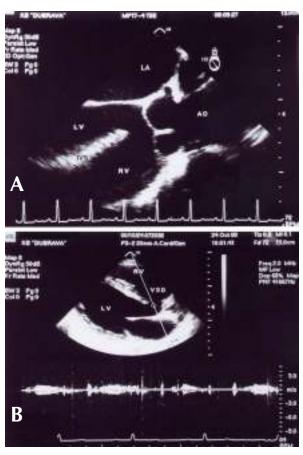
Patient with tetralogy of Fallot and patent ductus arteriosus A. Transesophageal echocardiogram of perimembraneous ventricular septal defect, with overriding aorta. B. Continuous-wave Doppler assessment of flow through the large ventricular septal defect revealed a fairly low velocity jet during the systole, indicating near equalization of the right and left ventricular pressures. AO – aorta; IVS – interventricular septum; LA – left atrium; LV – left ventricle; RV – right ventricle; VSD – ventricular septal defect.
